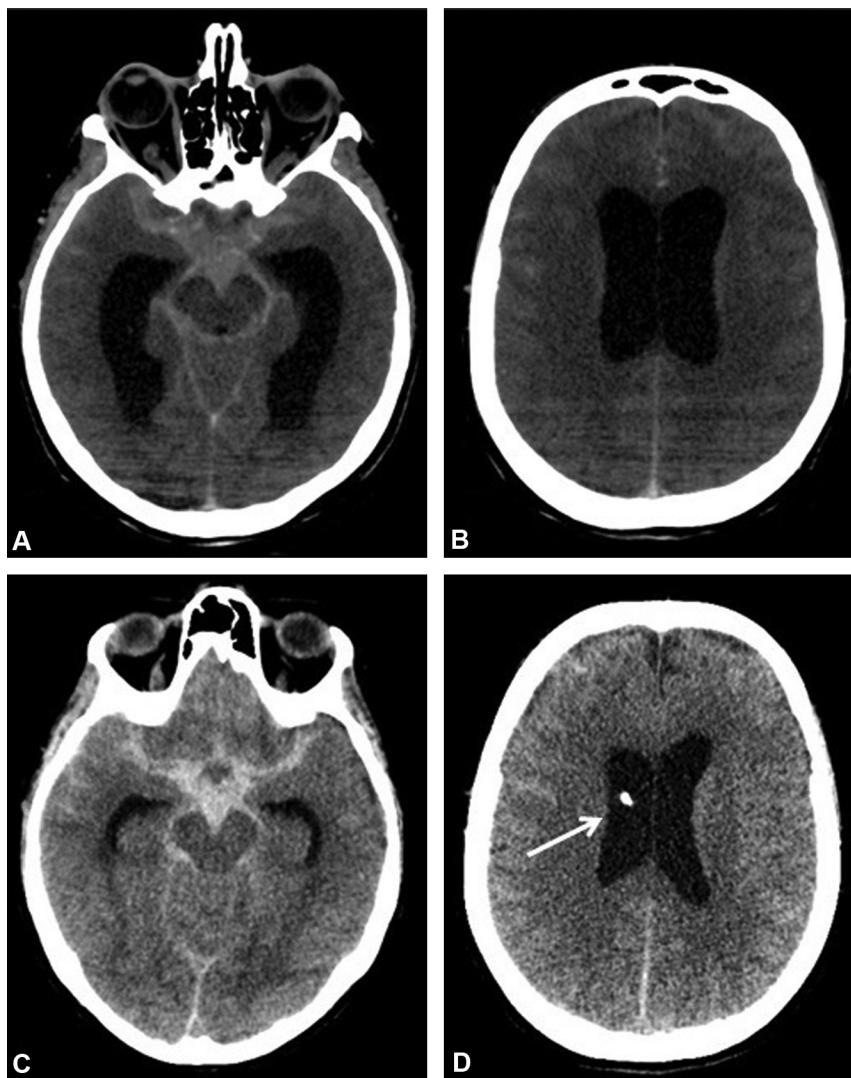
Fifty-one year old woman with sudden-onset headaches. Unenhanced cerebral CT shows hyperattenuating area in the motor cortex sulci and perimesencephalic cisternae with ventricular involvement and dilatation of the ventricular system suggestive of Fisher grade 4 subarachnoid hemorrhage complicated by acute hydrocephalus (A, B). Insertion of an external ventricular shunt cannula (D, arrow) before endovascular treatment reducing the ventricular volume seen on the immediate postoperative CT (C, D).
